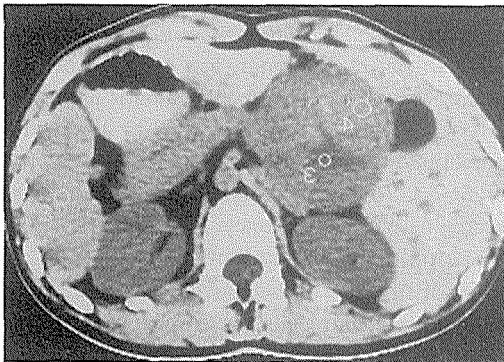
CT image of a well-defined neoplastic mass in the pancreatic head, measuring 7.2×8.1 cm, with attenuation coefficients from 25 to 49 HU. The right hepatic lobe was slightly compressed and dislocated anterosuperiorly and the right kidney was dislocated inferoposteriorly.
